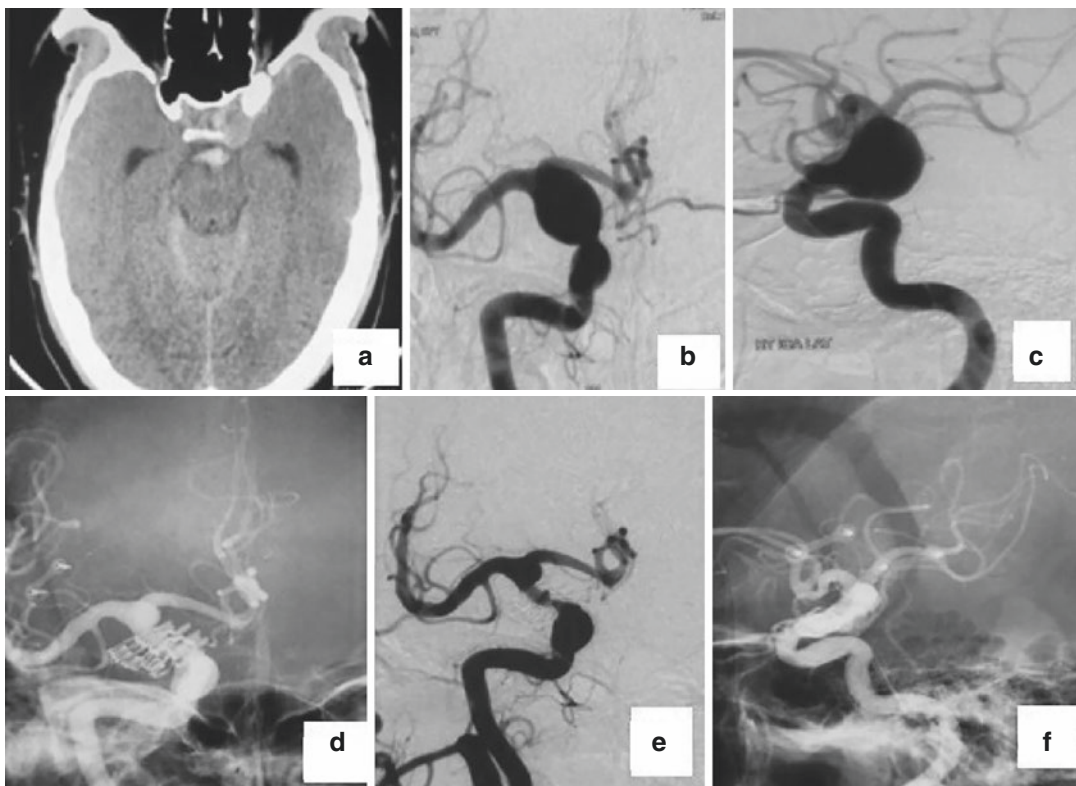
(a) Shows CT brain plain shows WFNS grade II SAH. (b, c) Shows DSA with a large distal ICA aneurysm. (d, e) Showing postop angiogram and DSA with the clipped aneurysm. (f) Complete obliteration of the aneurysm
